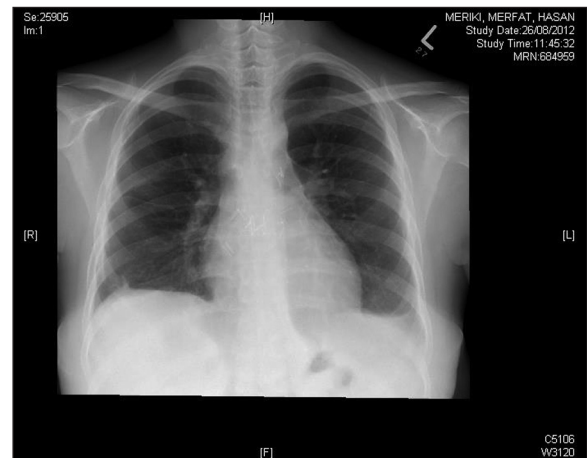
Chest X-ray 24 months post-re-pleurodesis and sirolimus treatment
